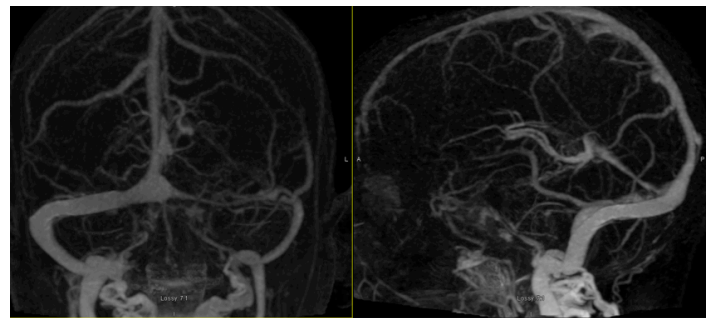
Dynamic CT Venogram follow-up. Antero-posterior and lateral view demonstrating normal caliber of the right transverse sinus after stent placement with no in-stent stenosis.
